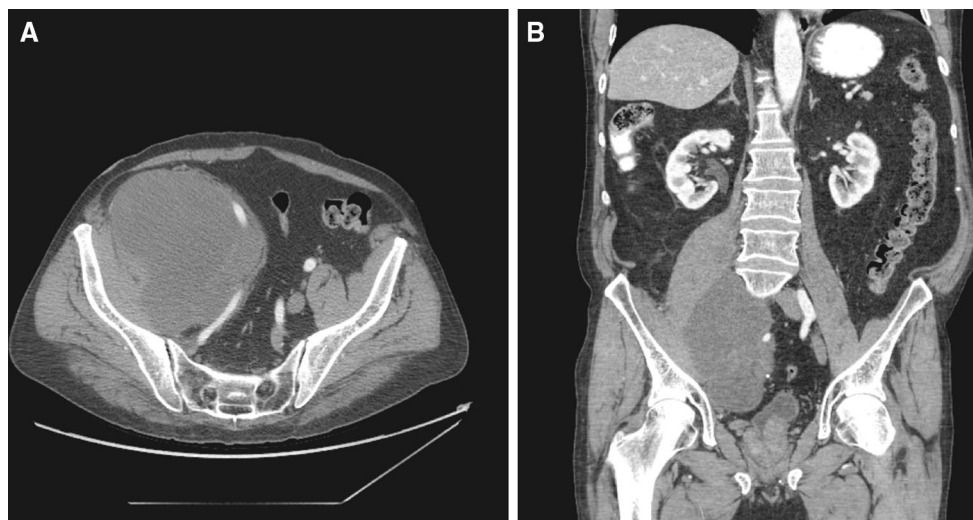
Contrast-enhanced abdominal computed tomography depicting high-grade unclassified pleomorphic sarcoma. From (a) axial and (b) coronal images, this tumor could be arising from psoas muscle, iliacus muscle, or even iliac vasculature
